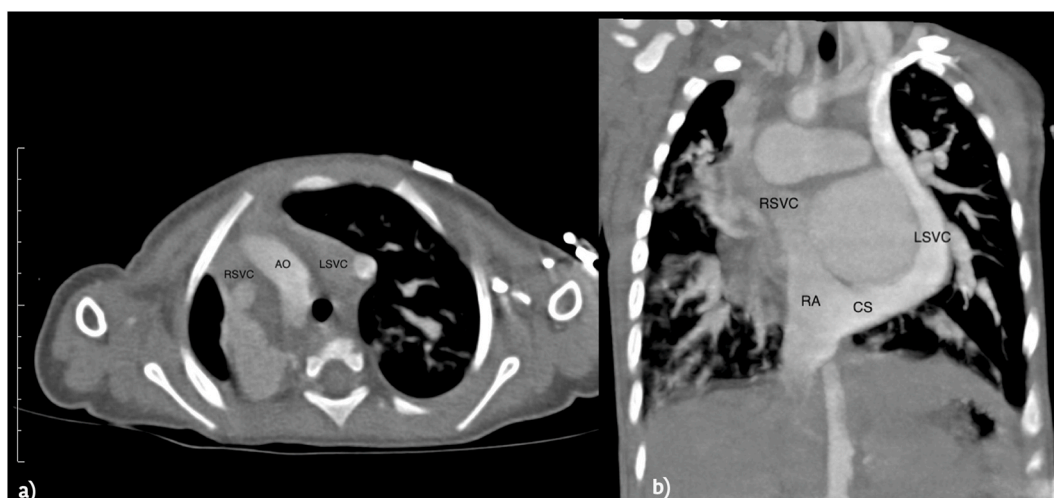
Contrast-enhanced computed tomography para-axial (a) and para-coronal (b) MPR reconstruction of a duplicated SVC in a patient with dextrocardia in situs solitus. RSVC = Right superior vena cava; LSVC = Left superior vena cava; RA = Right atrium; CS = Coronary sinus.
